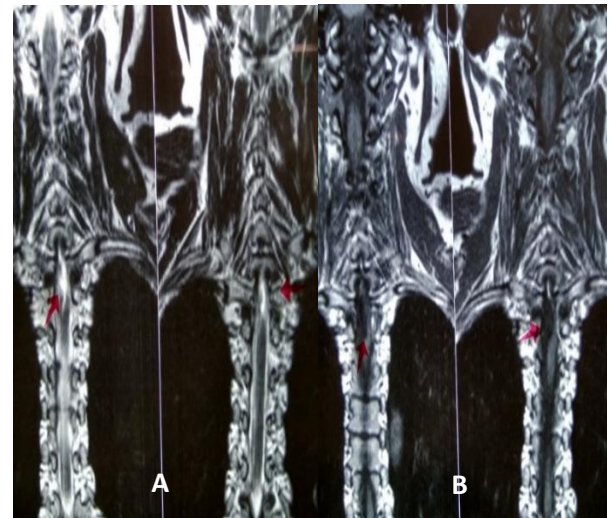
A) T2 sagittal magnetic resonance imaging (MRI) revealing focal ventral spinal cord herniation through a dural defect at D2-D3; B) T1 sagittal MRI revealing focal ventral spinal cord herniation through a dural defect at D2-D3
